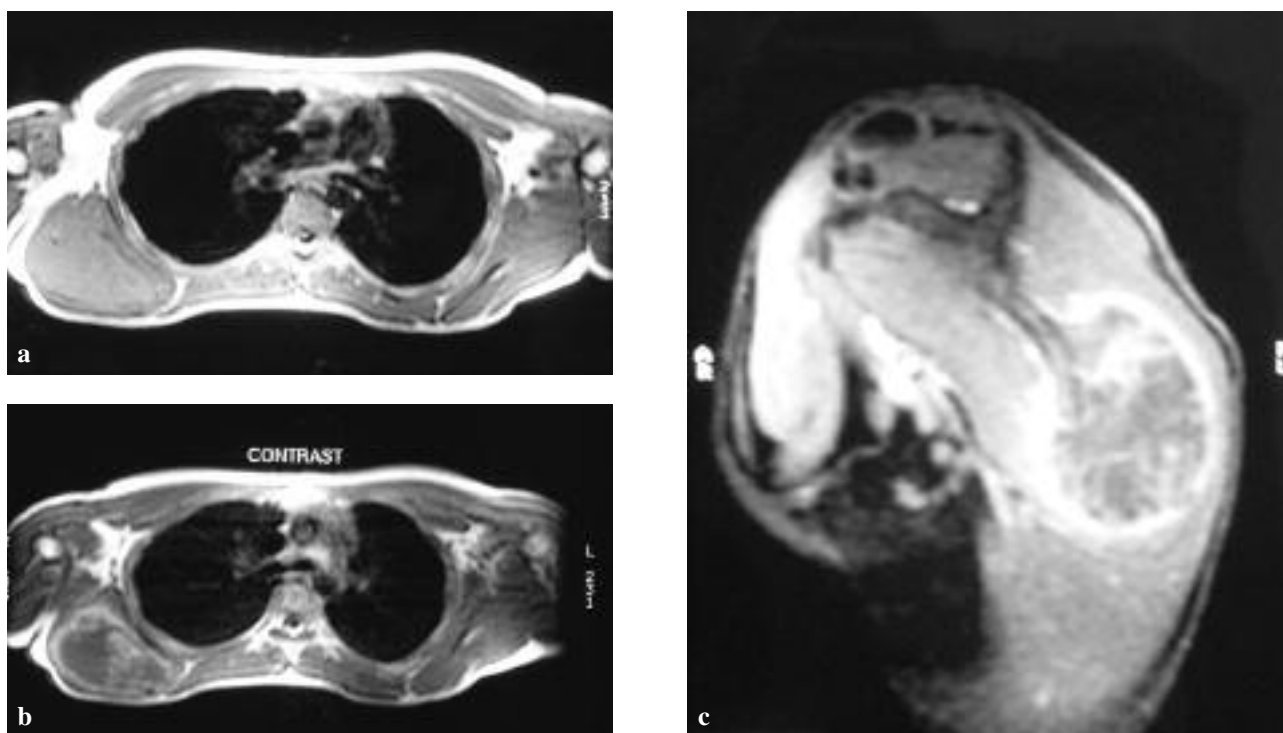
MRI Images : On pre-contrast T1 Spin Echo images the lesion shows intermediate signal intensity. The periphery of low intensity corresponds to a thin and intact “shell”. Post contrast T1 SE and T1 with Fat Saturation images demonstrate marked marginal enhancement. Internal septations are better delineated on post-contrast images.
